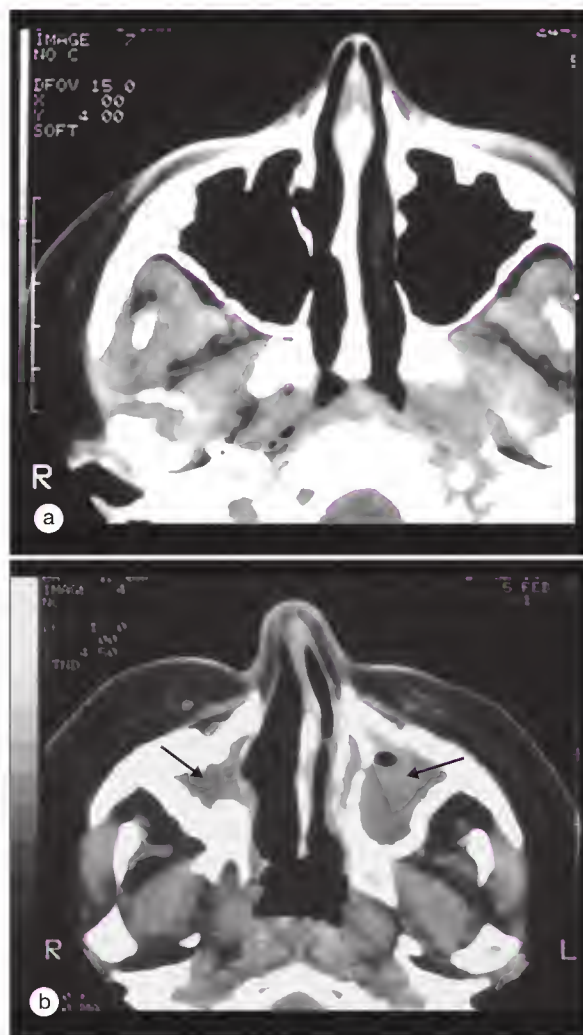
(a) Computed tomographic (CT) image showing normal maxillary sinuses in a patient recently diagnosed with granulomatosis with polyangiitis (GPA). (b) CT image for a patient with longstanding GPA showing nasal septal deviation, destruction of the medial walls of the right maxillary sinus, opacification of both sinuses (arrows), and neo-ossification of all maxillary bony structures due to chronic inflammation.
